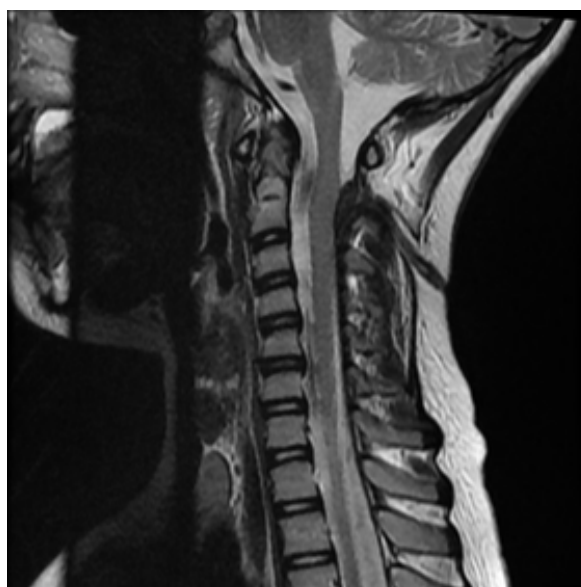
MRI section shows dermal sinus tract.
